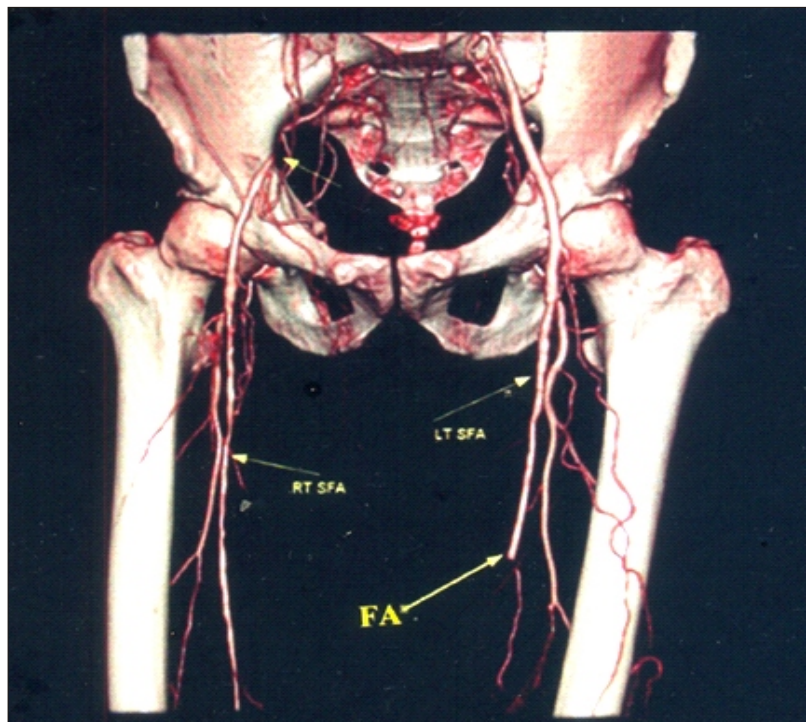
CT angiogram showing superficial femoral artery obstruction
